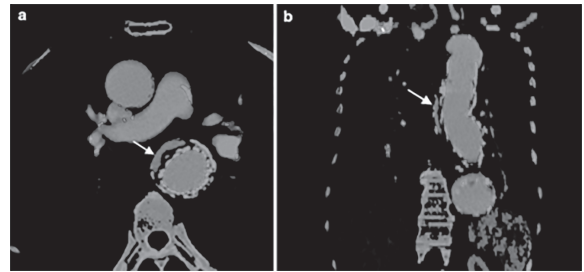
Axial (a) and coronal (b) slices show that Iodine (blue) is detected in the aneurysm and outside the Graft Stent. This corresponds to a type I endovascular fistula derived from the distal end of the Stent Graf. (Source: Sommer WH. *Aorta Dual Energy CT in Clinical Practice*. 2011:61-6.)(18)
